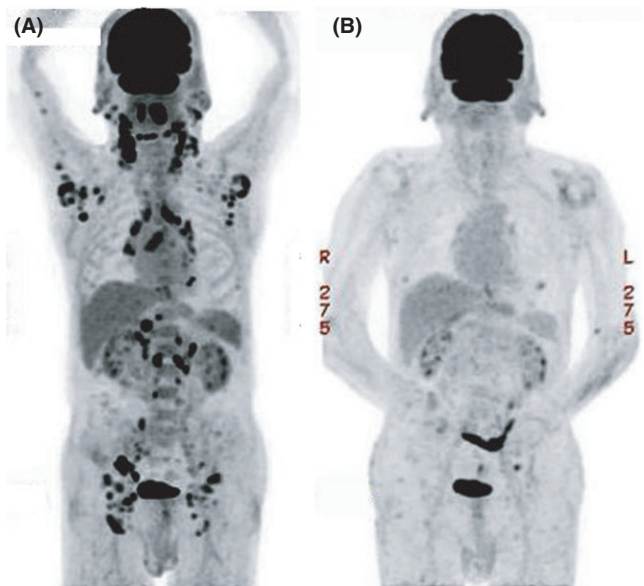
Images of ^{18}F -FDG PET-CT at (A) initial examination and (B) 3 months after withdrawal of MTX. A, The increased uptake of ^{18}F -FDG is observed in multiple lymph nodes. B, The uptake of ^{18}F -FDG in lymph nodes markedly diminishes
